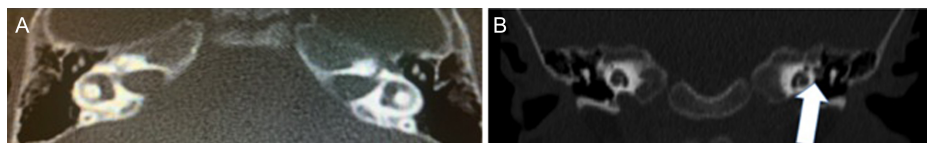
CT scan shows an enlargement of the left FN at the level of the GG in the axial view, white matter arrow (A) and in the coronal view, white matter (B). CT, computed tomography; FN, facial nerve; GG, geniculate ganglion.
